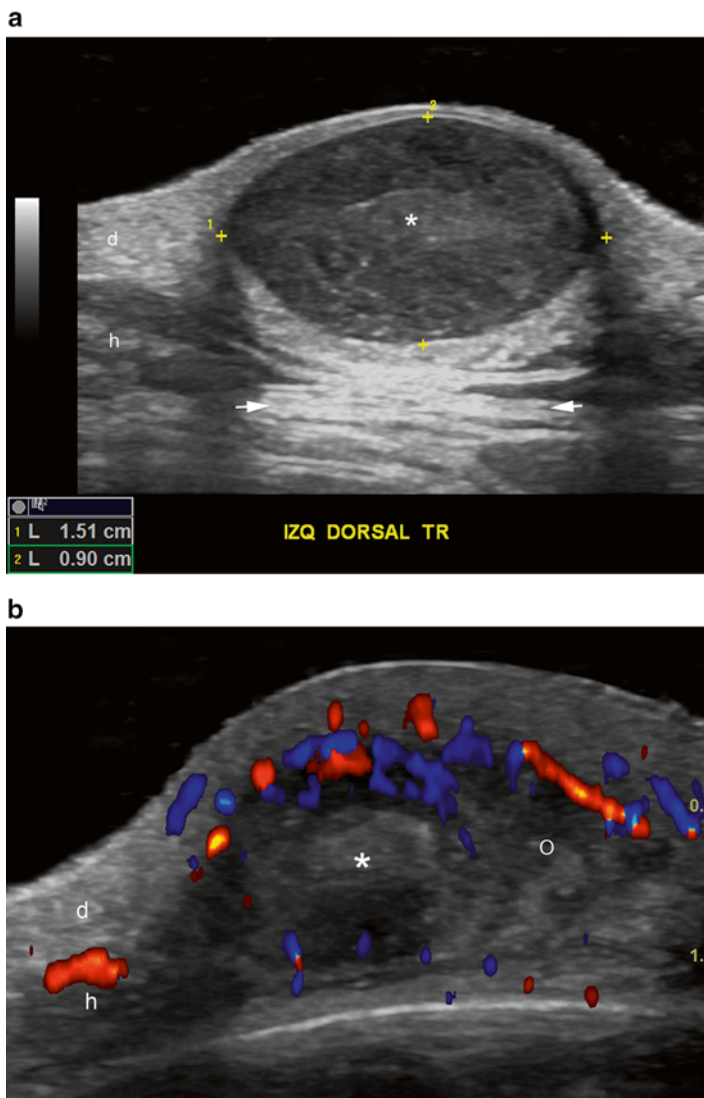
(a) (Top). Epidermal cyst, intact. Hypoechoic oval shaped structure (*) in the dermis and hypodermis with posterior acoustic enhancement artifact (arrows). (b) (Bottom). Ruptured. On color Doppler the cyst (*) presents inflammation and there is spreading of the keratinous material (o) in the right aspect of the image. (d=dermis; h=hypodermis)
